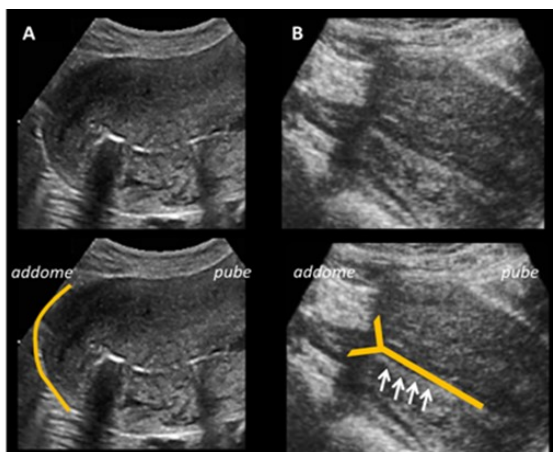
Ultrasound appearance of the uterus with fundus inversion
